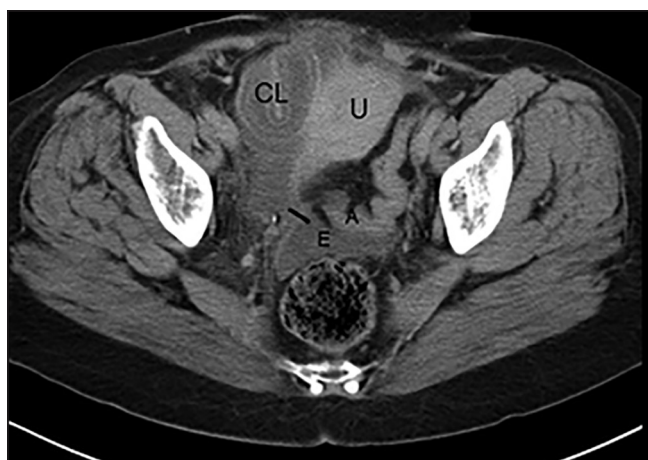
Computed tomography scan shows small bowel obstruction due to a broad ligament hernia (the black line at the defect), which is a closed-loop small bowel obstruction with a whirlpool sign closed loop (CL). The hernia located anterior to the uterus (U) pushing the uterus laterally to the left. Efferent and afferent ileal limbs (E and A, respectively.)
